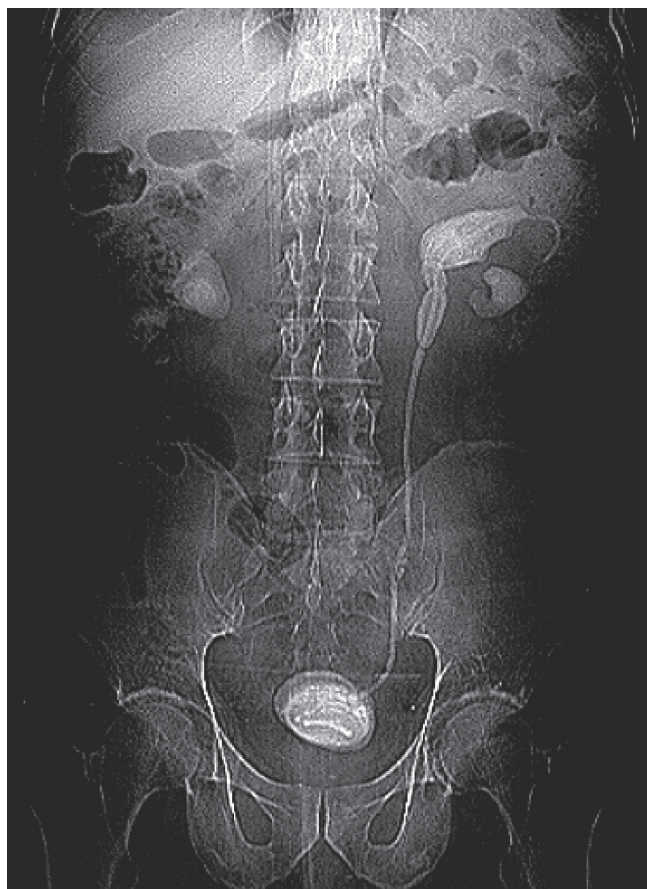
X-ray of kidneys-ureters-bladder (KUB) showing overdue stent on left side with severe encrustation along with bladder stone and partial staghorn calculus on right side
